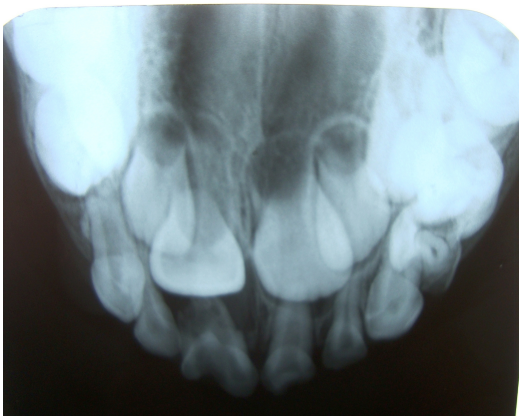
Occlusal radiograph showing double teeth with two roots and two canals with extensive root resorption.
